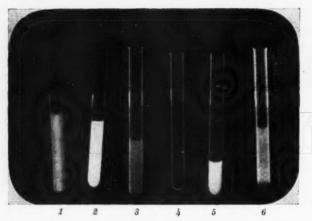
Various roentgen-opaque solutions. 1, Iodipin, 50 per cent; 2, Lipiodol, 33 per cent; 3, Neosilvol, 30 per cent; 4, Sluder Oil, clear; 5, Argyrol, 20 per cent; 6, Mercurochrome, 2 per cent.
